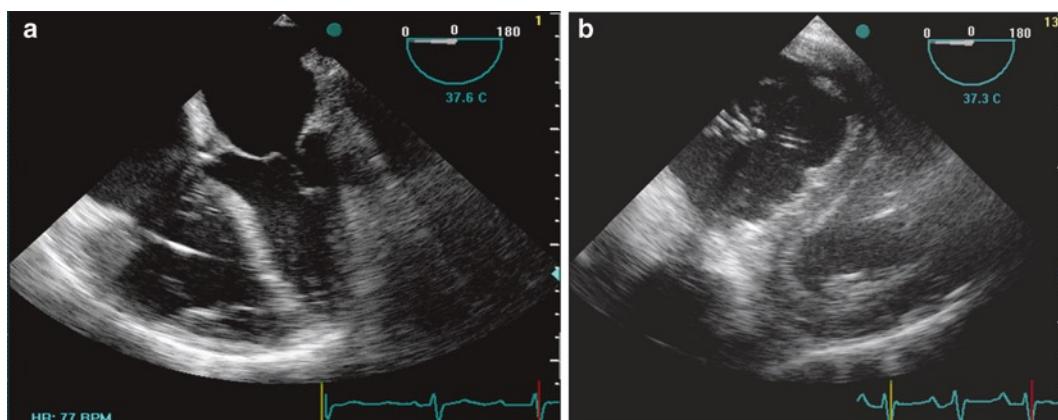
Transesophageal echocardiography of right ventricular dilatation with classical flattening of the interventricular septum and shift toward the left ventricle, seen in the (a) mid-esophageal four-chamber and (b) transgastric short-axis views.
